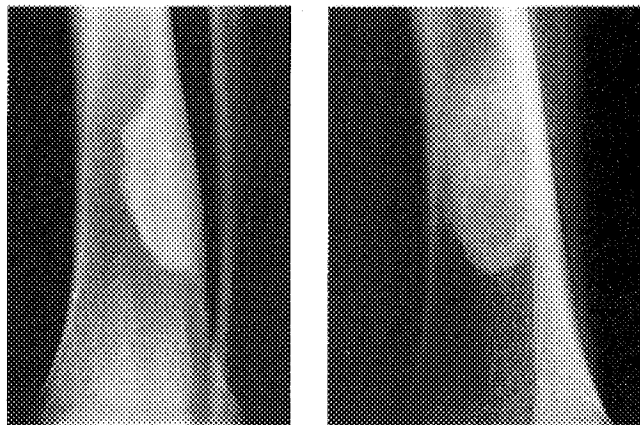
AP, left, and lateral, right, radiographs of the distal tibia, showing an ossified eccentric metaphyseal lesion that is a healed nonossifying fibroma. This is a latent (stage-1) lesion.
